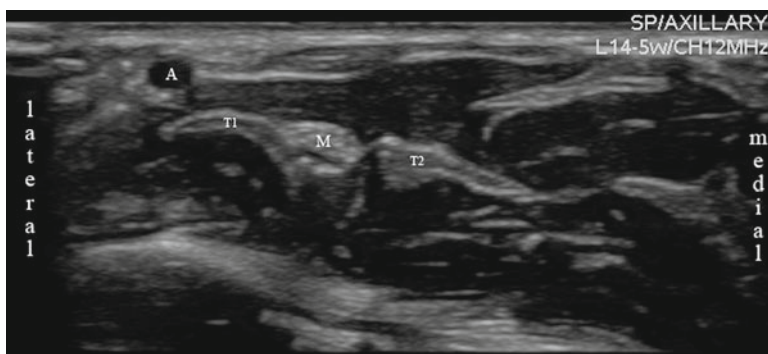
Ultrasonographic appearance of the median nerve at the wrist (*A* radial artery, *M* median nerve, *T1* tendon of the flexor carpi radialis muscle, *T2* tendon of the palmaris longus muscle)
